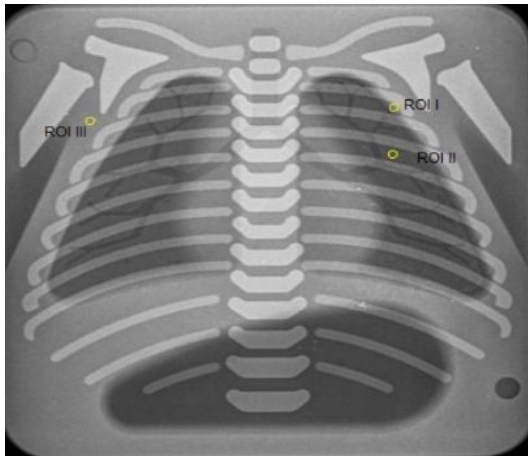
2 ROI placements in radiograph
